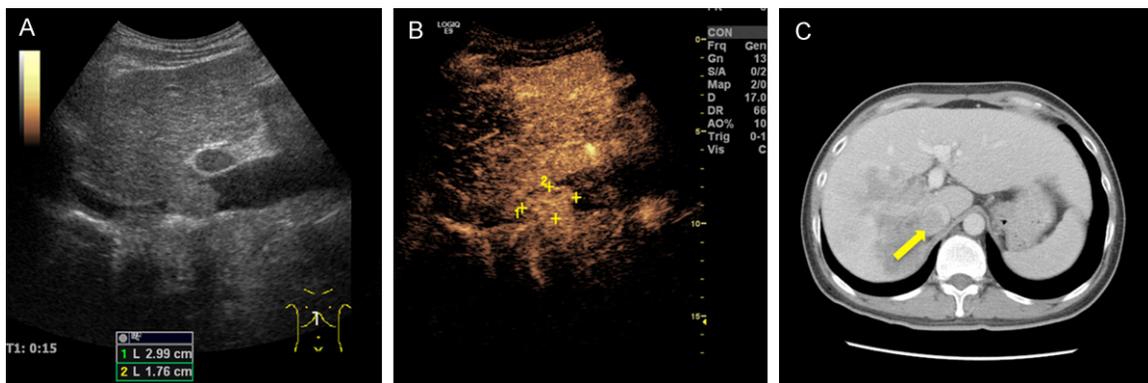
PVTT in the inferior vena cava. A: Conventional ultrasound imaging. B: CEUS imaging. C: Enhanced CT imaging.
